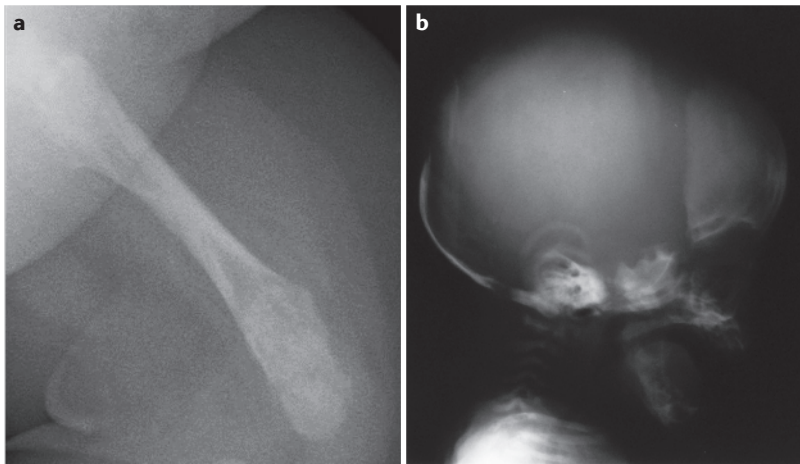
Radiographic features of infantile hypophosphatasia. a | Radiograph of the left femur of a 3-month-old girl shows transition from a properly shaped segment of the diaphyseal shaft to hypomineralized and distorted proximal and distal metadiaphyses, which suggests a sudden metabolic change disrupting the more recently formed endochondral bone. b | Lateral radiograph of the skull of the same infant shows hypomineralization, especially posteriorly. Consequently, the fontanelles appear wide.
